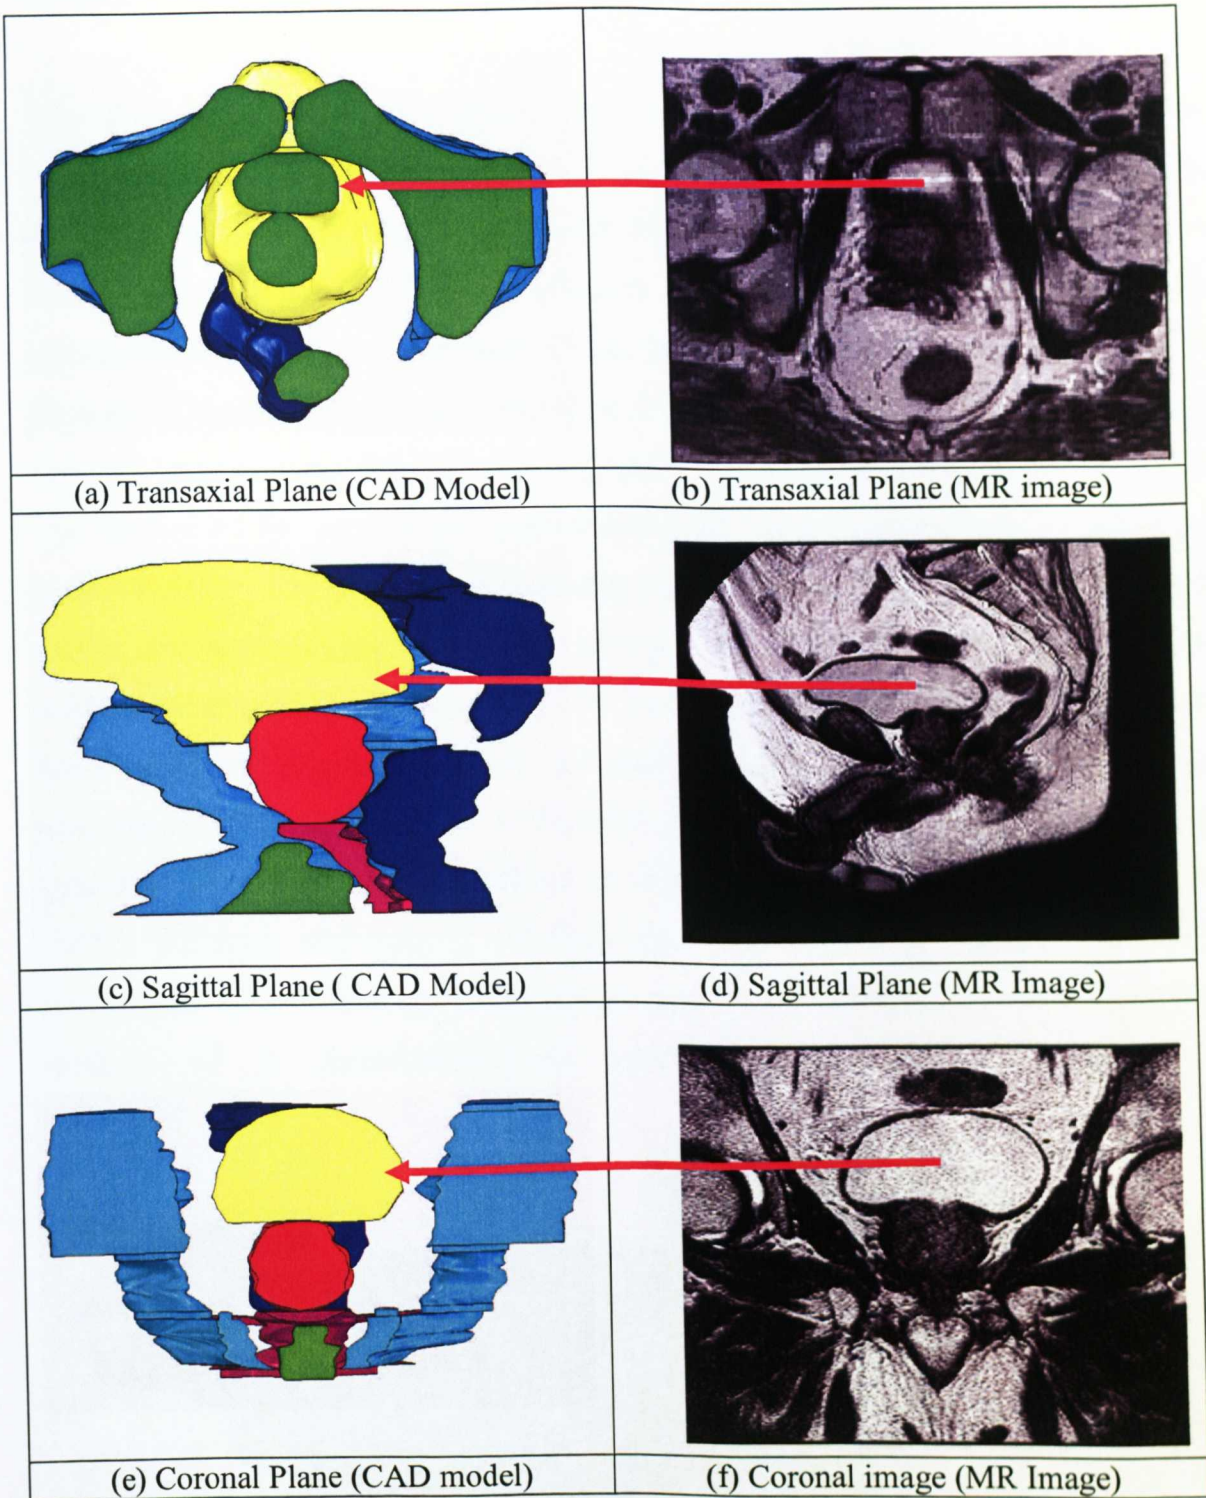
Comparison of the cross-sections of the solid model to MRI slides at different orientations/planes for Subject two. (not to scale to preserve full MRI slice, the arrows indicate the position of the bladders).
